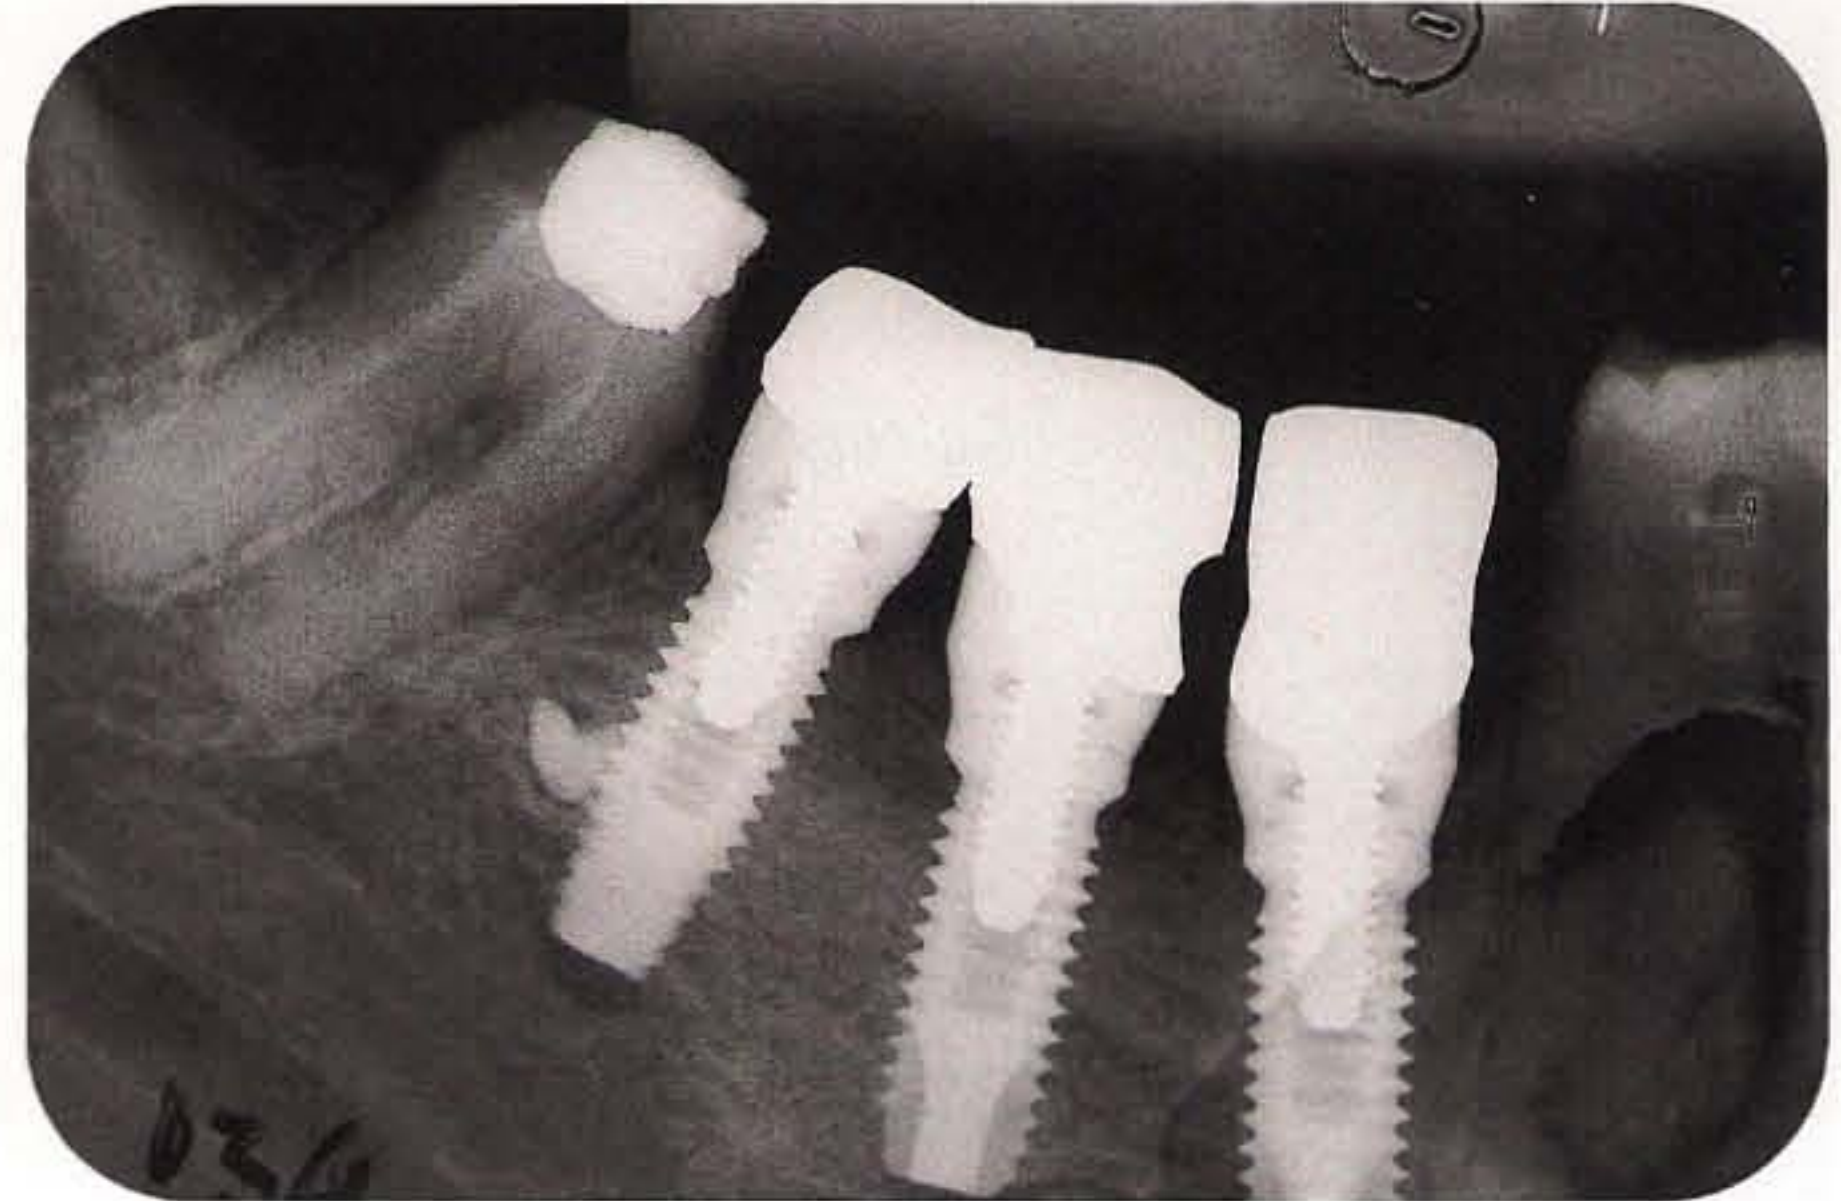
Radiograph 12 months after the prosthesis was placed.
